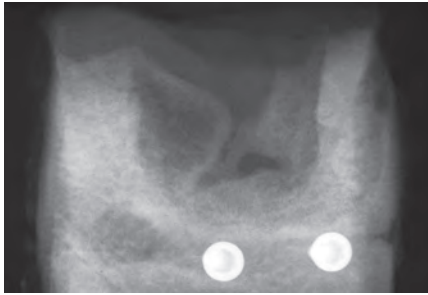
Radiograph of a membrane-covered defect after 2 months shows bony ingrowth from the mesial and distal walls, as well as from the bottom of the defect. (Reproduced with permission from Schenk et al.¹²³)
